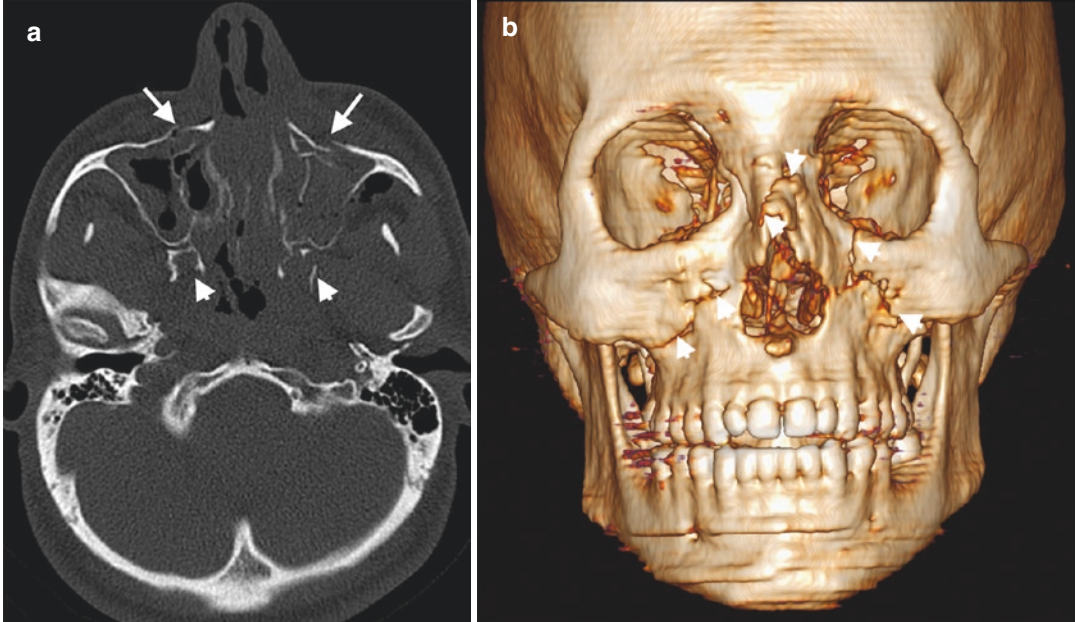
Le Fort II fracture. (a) Axial CT image demonstrates bilateral maxillary sinus fractures (arrows) and pterygoid process fractures (arrowheads). (b) VR image reveals Le Fort II fracture (arrowheads) with pyramidal shape
